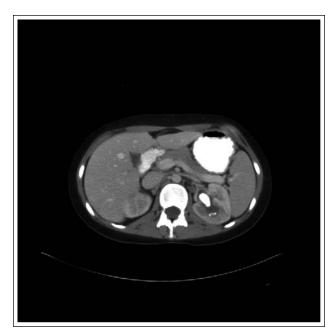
Computed tomography scan displaying 3 cm left renal pelvis stone.
